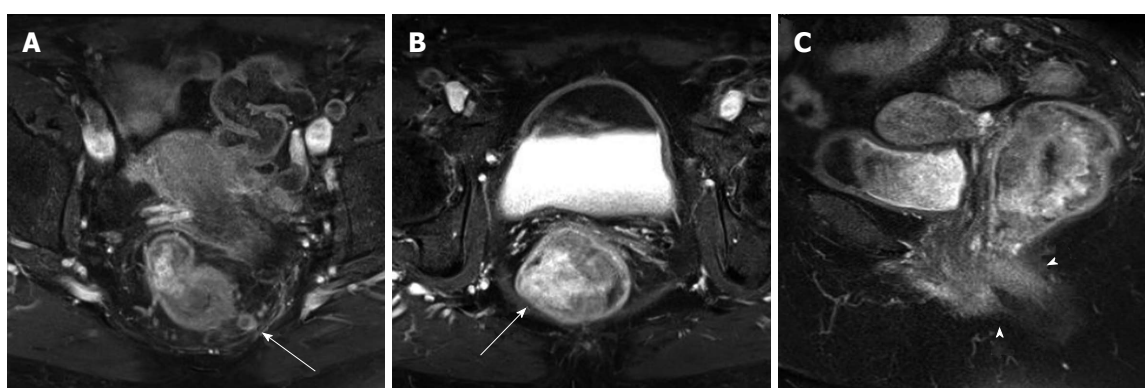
Abdominal magnetic resonance imaging for local staging of rectal adenocarcinoma in a 58-year-old female. A, B: Post-contrast fat-suppressed axial images show 7 cm long contrast enhancing neoplastic mass with lymph node metastases within the mesorectal fascia (arrow); C: Peripheral desmoplastic reaction (arrowheads) on T1 sagittal images.
